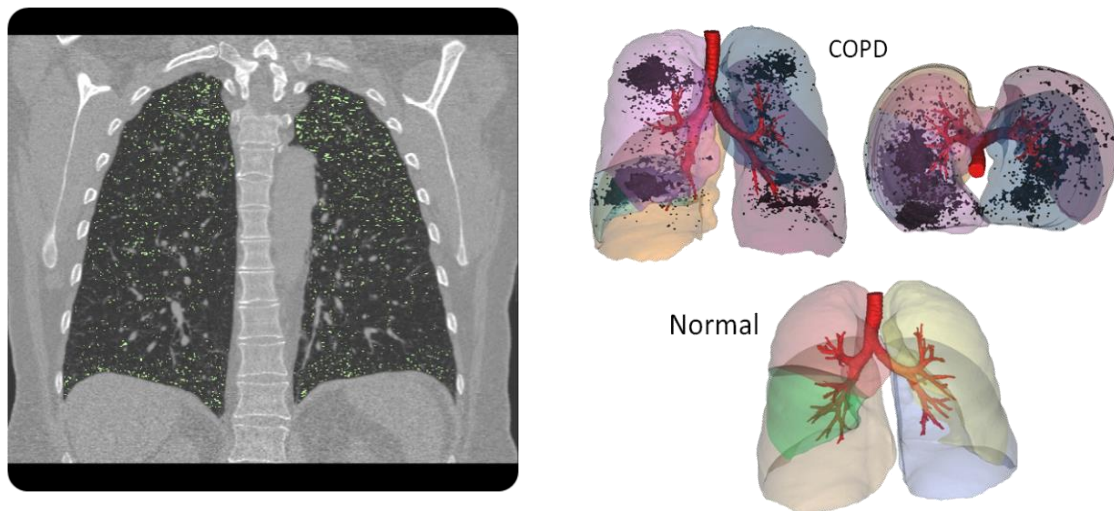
Quantitative analysis of emphysema in COPD patients shown in a CT shown on left and as 3D cloud compared with a normal subject on the right (Vinchurkar et al., 2012)
